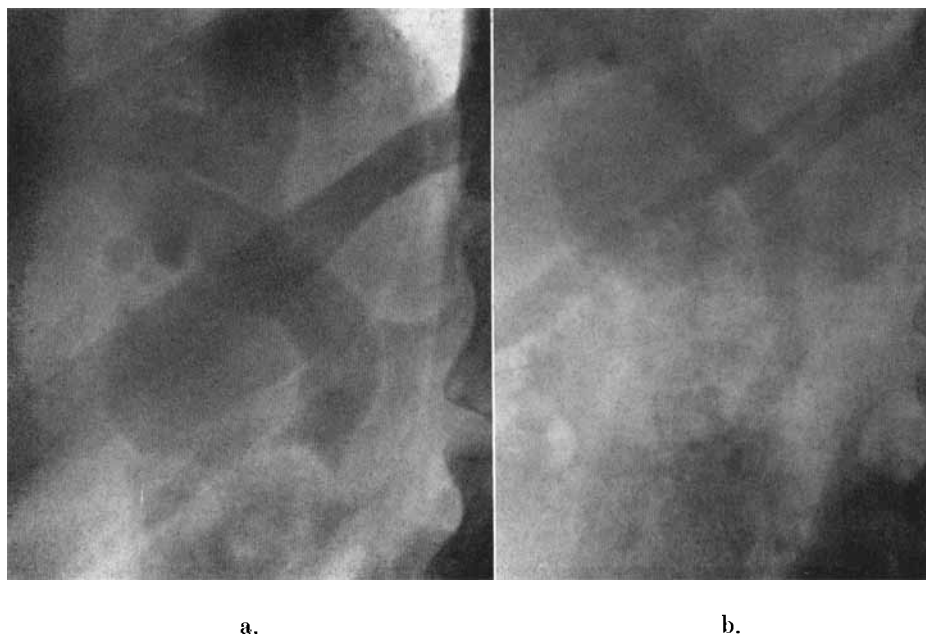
Case 2. Cholegraphy. a. Radiograph 80 min. after injection of 20 ml Biligradin 40 %. Visualization of an occluding stone at the papilla of Vater. Stasis in the biliary tract. b. Radiograph 40 min. after the injection of 20 ml Biligradin 40 %. Three months after removal of occluding stone: return to normal of bile flow.
